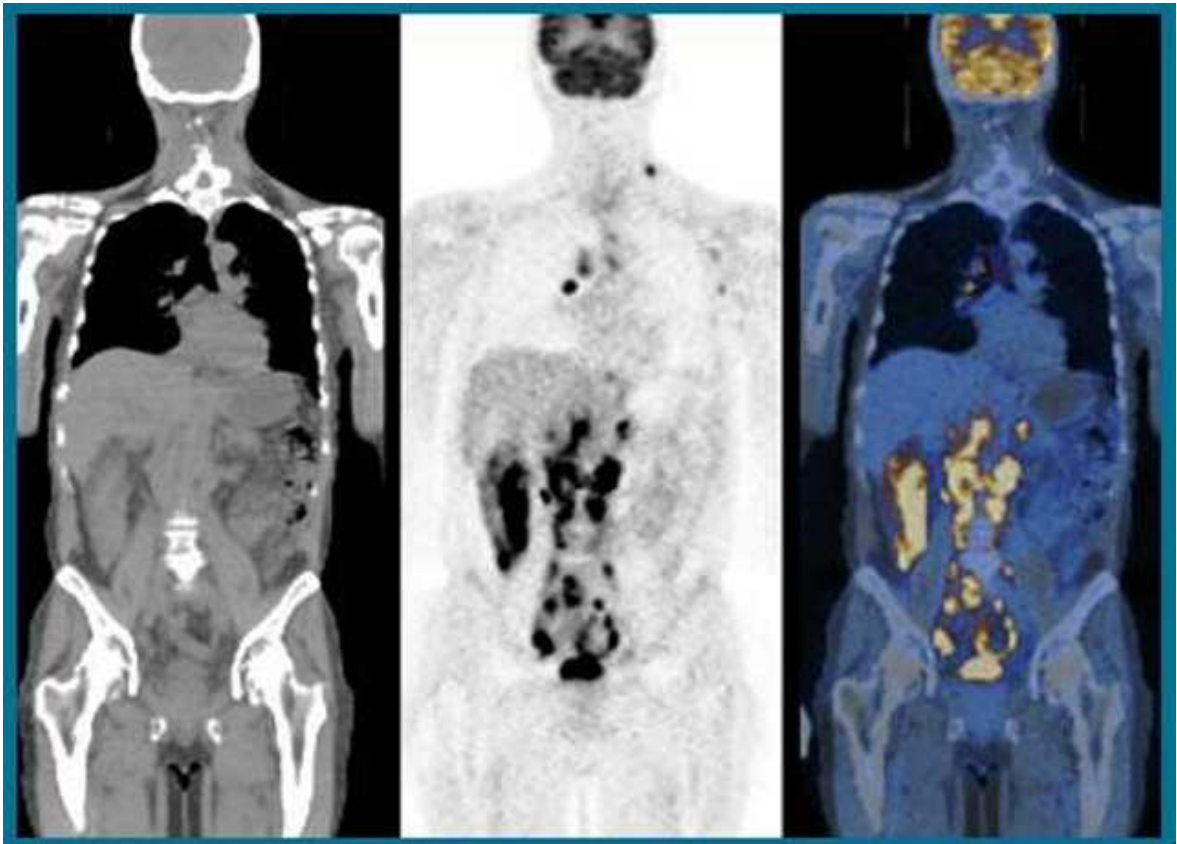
Registered PET-CT image. PET-CT has a wide usage area for cancer diagnostic. Since two hardware are attached to each other registration process is relatively easier and faster. Image (A) is CT image, image (B) is PET image, image (C) is CT fused PET Details are in section 1.4.1
